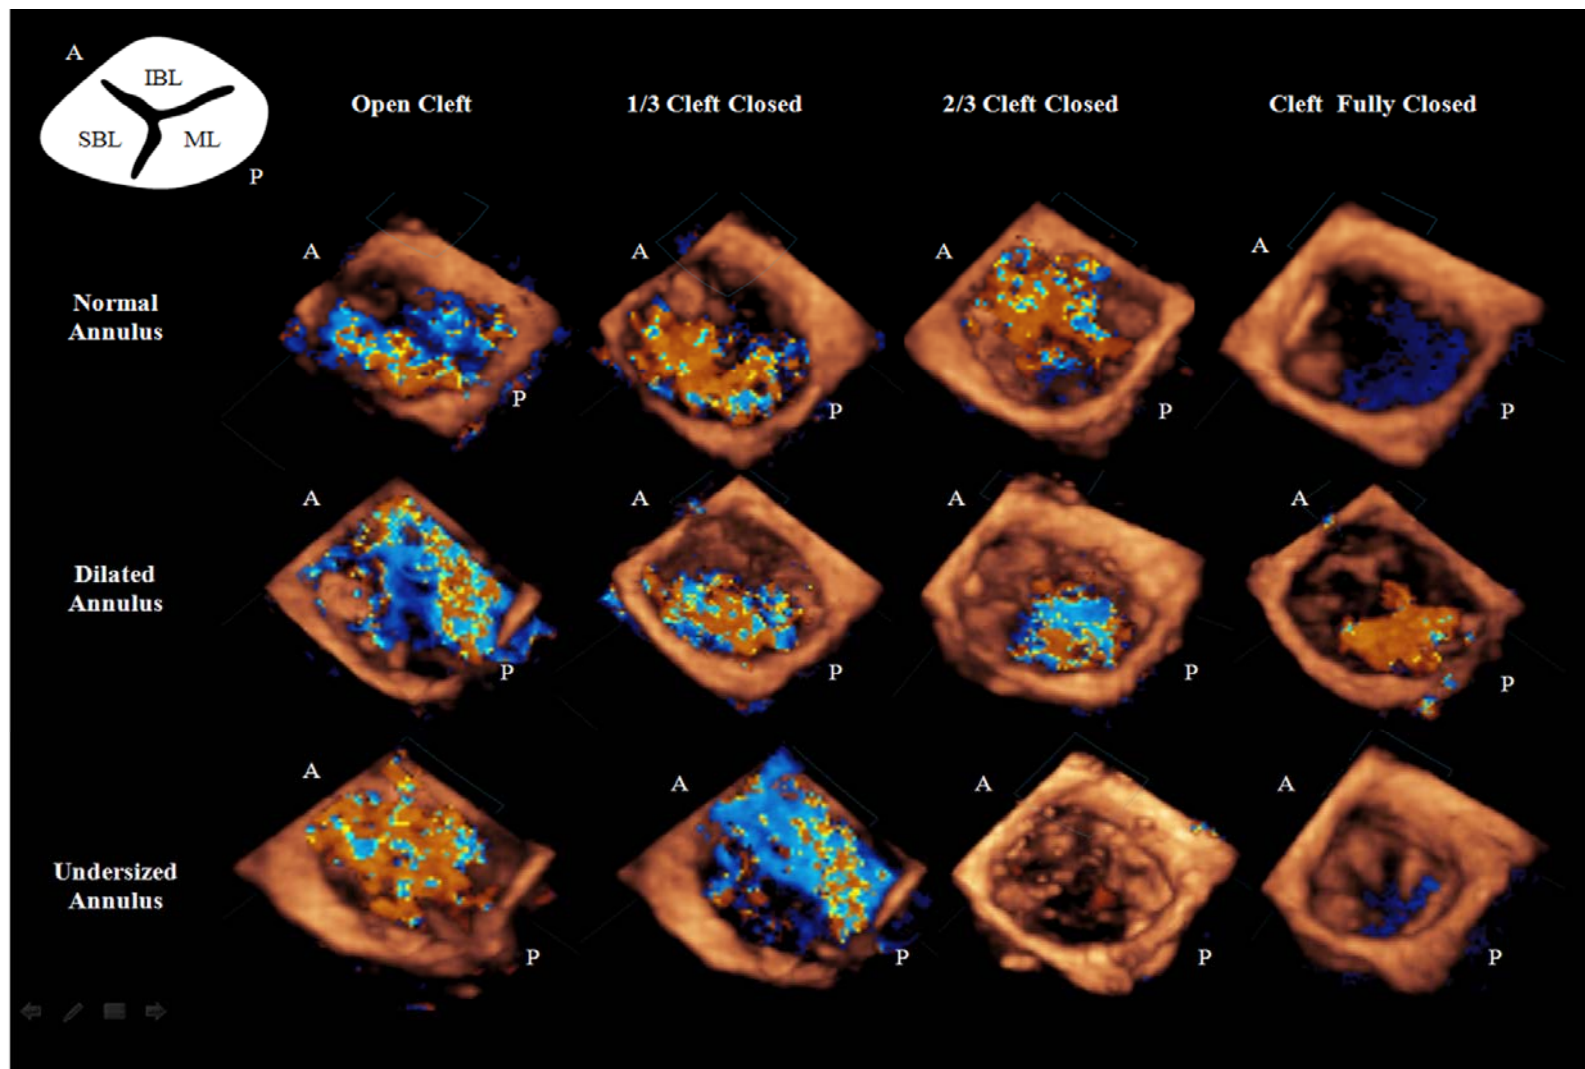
Color Doppler images of the cleft mitral valve at different cleft closure lengths and annular sizes, depicting the regurgitation jets through the valve.
